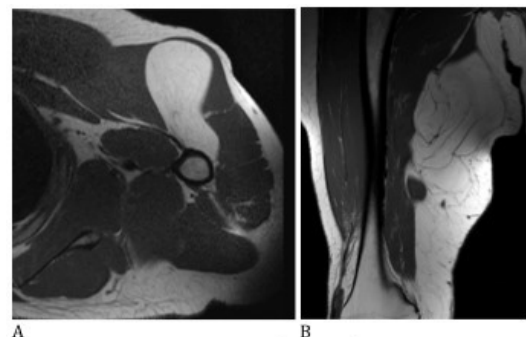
Representative MR imaging of Lipoma and WDL
